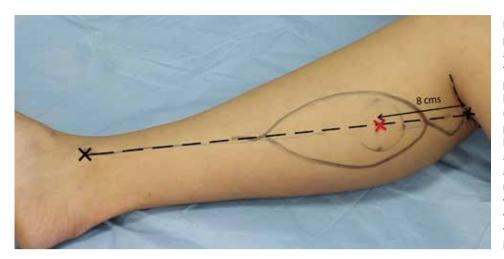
Midpoints on the popliteal crease and malleolus are marked and a line between them is traced. 8 cm distal to the popliteal crease, over the same line, a point is also marked out (red cross). Emerging points of perforator vessels are usually found inside a circle of 2 cm around this point. However, this anatomical landmark is approximate and not very accurate. Even when assisted by a Doppler device, the selected perforator has to be seen and identified before incising the entire skin paddle.
